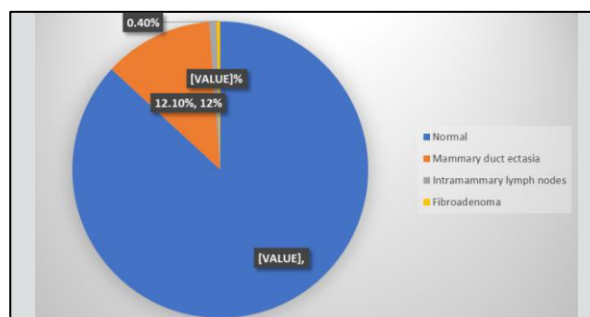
Ultrasound Findings in Patients without a Clinically Palpable Lump. n=203
